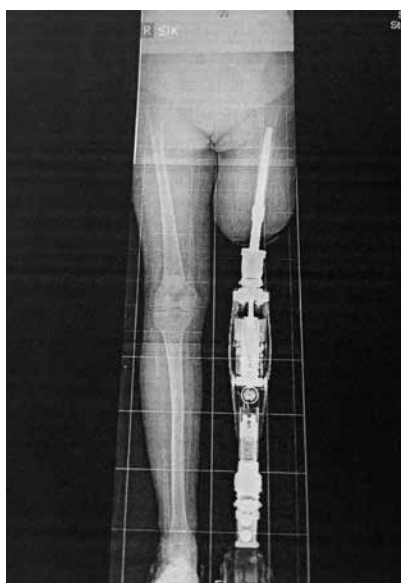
X-ray image with implant and attached prosthesis.
